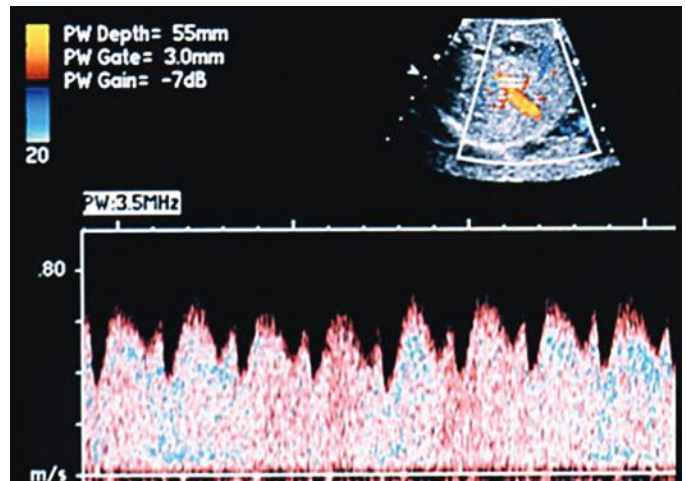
Doppler waveforms of the ductus venosus in a normal fetus in the third trimester of pregnancy. Note the presence of forward flow within the ductus venosus throughout the cardiac cycle.
